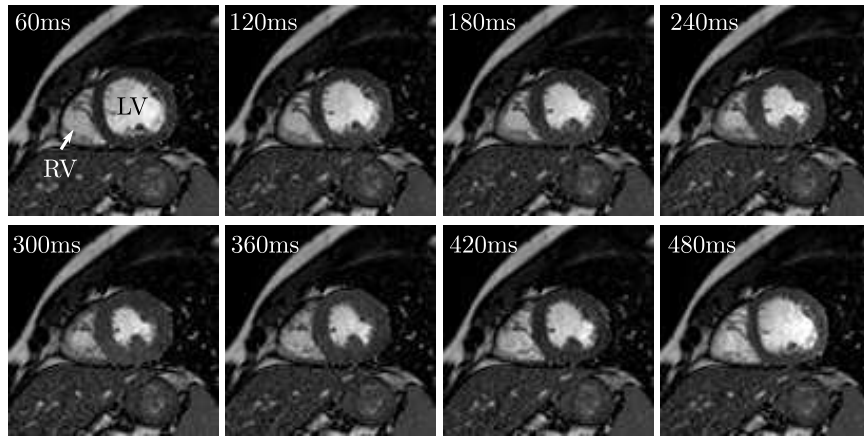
Cine MRI short axis views showing the contraction of the ventricles during systolic contraction and diastolic relaxation. Data was acquired with a bSSFP sequence yielding an excellent contrast between blood pool and myocardium, and high SNR. The time in milliseconds is relative to the previous R-peak. LV/RV left/right ventricle
